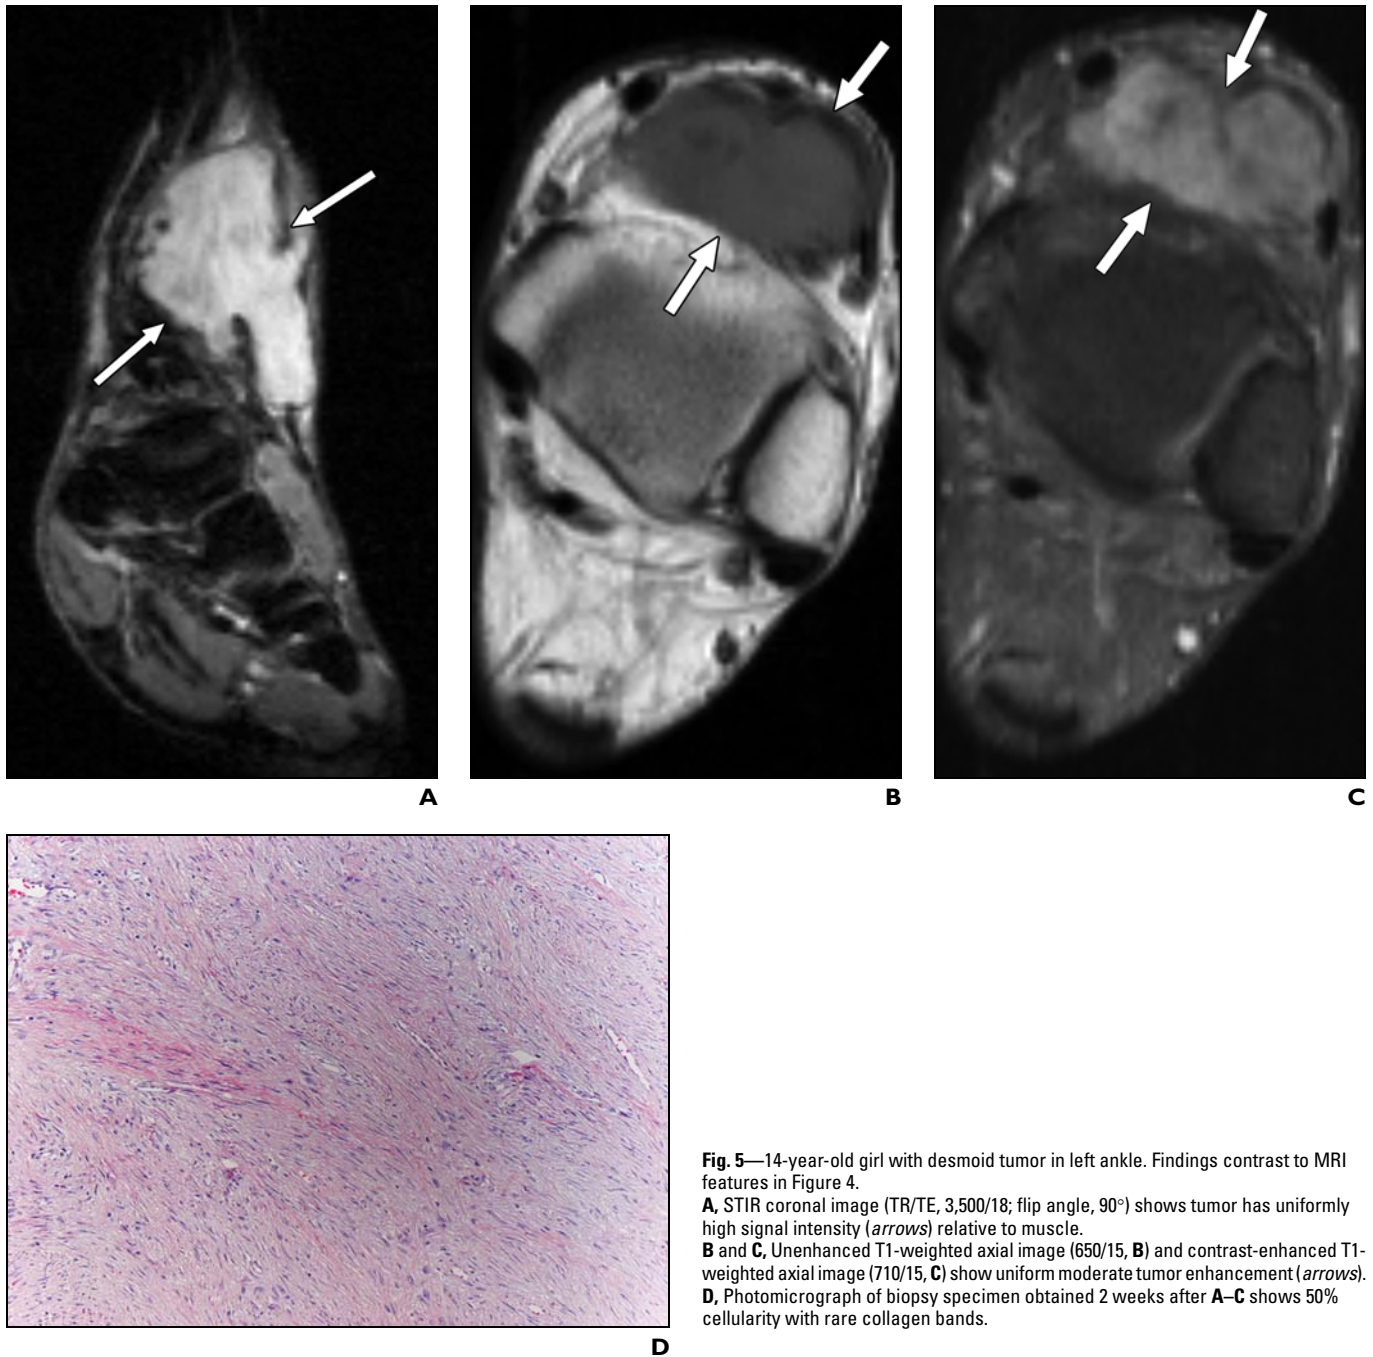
14-year-old girl with desmoid tumor in left ankle. Findings contrast to MRI features in Figure 4.
